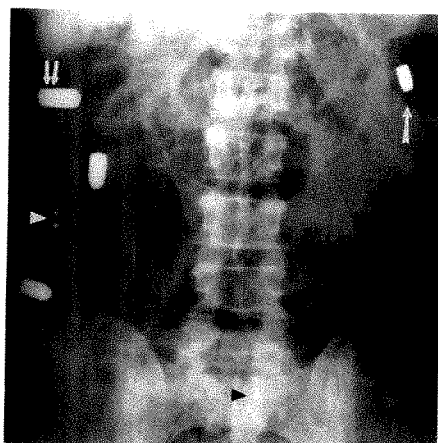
Abdominal radiograph after handgun and shotgun injuries shows four undeformed handgun bullets and three shotgun pellets (arrowheads). Three bullets are of same type, with rounded tips and cannalures (small arrows). Fourth bullet has a flat tip (large arrow). Although the two different types of bullets appear to be of different calibers (and thus fired from different guns), no such statement can be made without consideration of the magnification factors. Jacketing cannot be determined because of lack of deformation in soft tissues.
